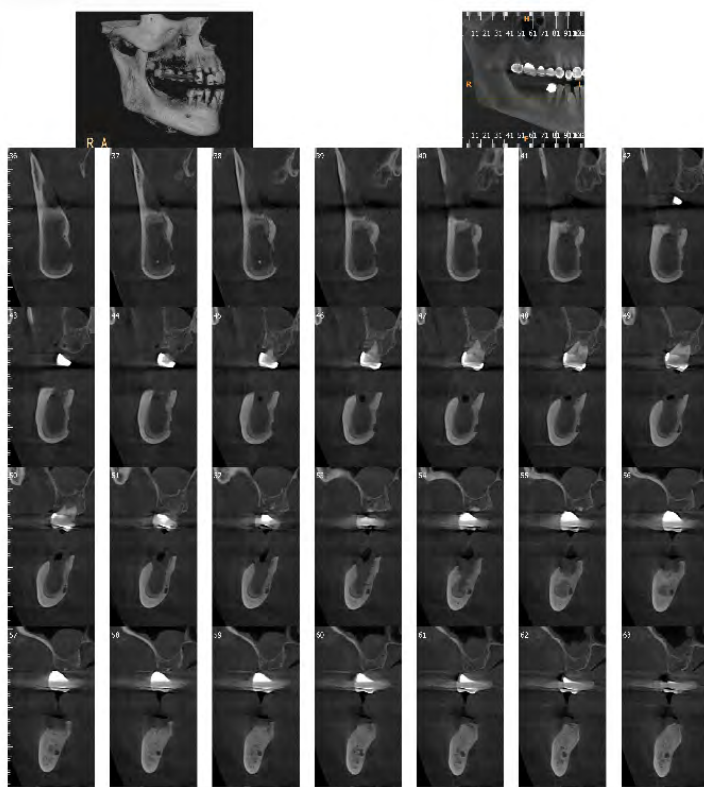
CBCT evaluation following marsupialization.
